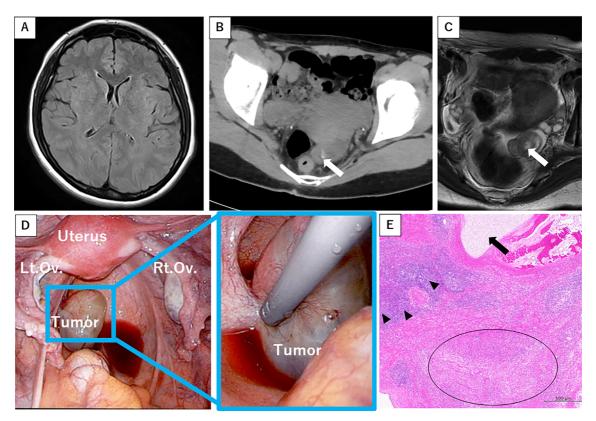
(A) Brain MRI fluid-attenuated inversion recovery showed no definitive lesion. (B) Pelvis CT scan, indicating a mass lesion with calcification in Douglas' pouch. (C) Magnetic resonance imaging (MRI) of the pelvis, revealing a mass lesion in Douglas' pouch. (D) On laparoscopy, the tumor was identified as originating from the peritoneum of Douglas' pouch, with bilateral ovaries exhibiting no evidence of pathology. (E) The mass in the pelvic region contained T cells (arrowheads), cartilage components (arrow), and nerve cells (circle).
